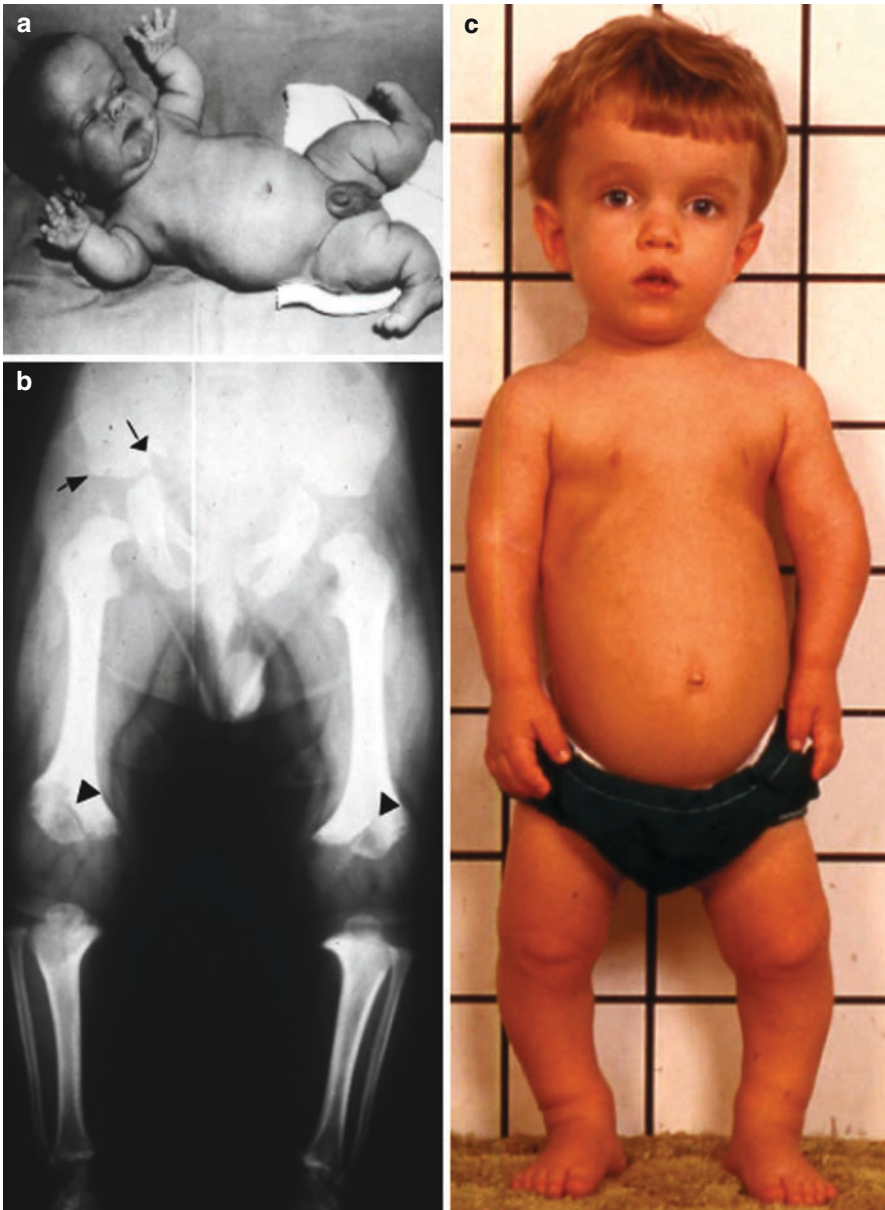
(a) Infant with achondroplasia who has macrocephaly with frontal bossing and flattening of the bones in the midface. The thorax is narrow and extremities are short, with bowing of the long bones in the legs. Note the joint laxity and redundant skin folds. (b) Radiograph from a child with achondroplasia showing squared off of the roof of the acetabulum and small sacrosciatic notches (*arrows*). The femur, tibia, and fibula are short with “chevron deformities” in the distal femur (*arrow heads*) caused by protrusion of the epiphysis into the metaphyseal space. In the distal portion of the leg, note the extension of the fibula beyond the end of the tibia. (c) Depicts a 3-year-old boy with achondroplasia, who has rhizomelic (proximal) shortening of the extremities, small thoracic cage, frontal bossing, and a flattened midface. Curvature of the tibia is evident. (Reprinted from Horton et al. [85]. Copyright 2007, with permission from Elsevier).
